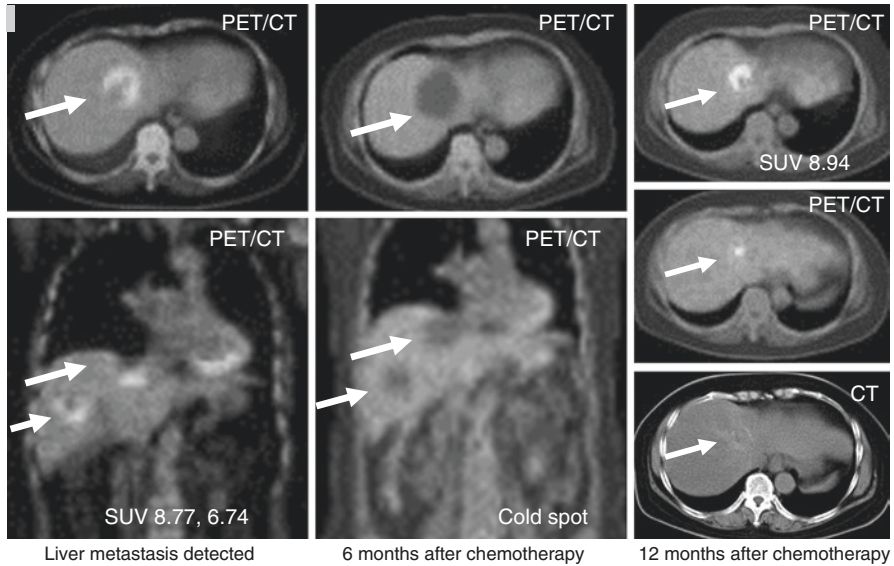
The patient was a 59-year-old woman with postoperative sigmoid colon cancer. Chemotherapy was performed for liver metastases. They were negative of accumulation in 6 months after chemotherapy and became positive for SUV in 12 months
